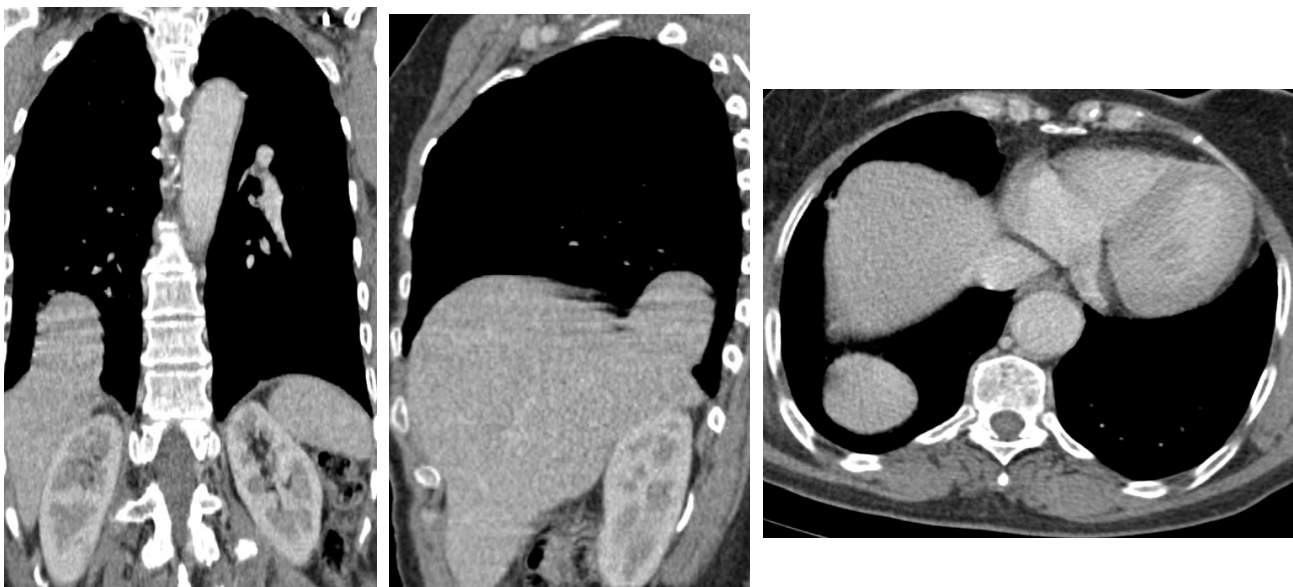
Thoracic CT coronal slice (A), sagittal slice (B) and axial slice showing a right postero-basal diaphragmatic defect with intrathoracic protrusion of part of the hepatic dome through a narrow neck.
